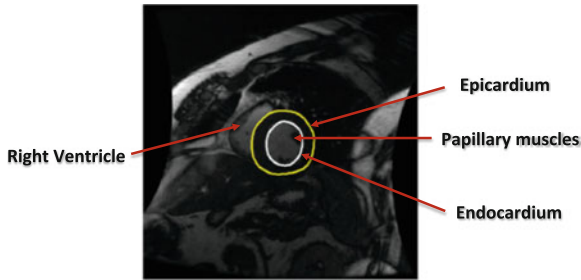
A typical short axis cardiac MR image containing LV, RV and papillary muscles
